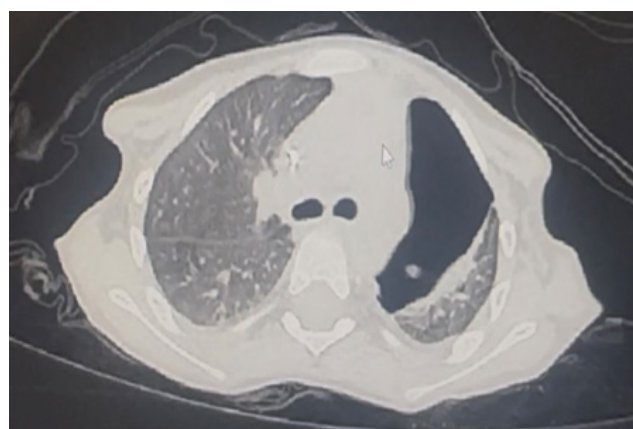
Post lobectomy CT
